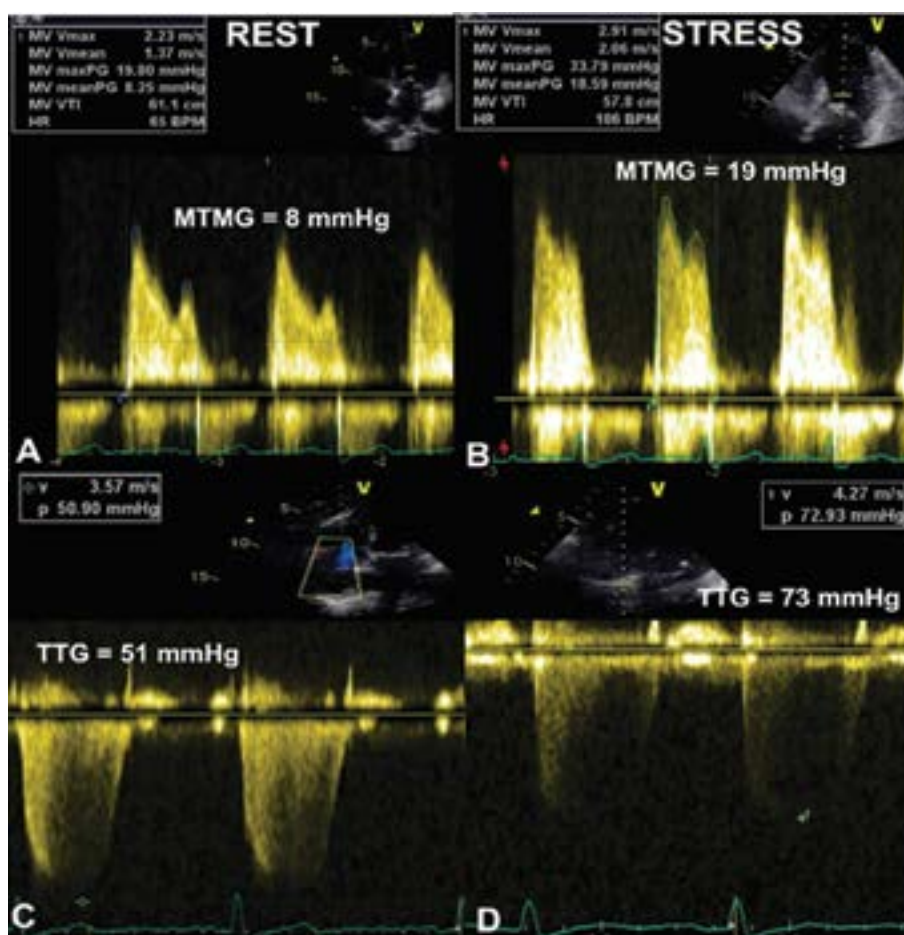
Doppler findings obtained by performing EE in an asymptomatic patient with moderate rheumatic MS (MVA 1.3 cm²) at rest (left panels). The increase in MTMG during exercise was significant (MTMG increased up to 19 mm Hg (A and B) with a significant increase in TTG up to 73 mm Hg (C and D) and exercise-induced dyspnoea. The patient underwent PMC; HR – heart rate; maxPG – maximal pressure gradient; meanPG – mean pressure gradient; MTMG – mean trans-mitral gradient; MV – mitral valve; MVA – mitral valve area; TTG – trans-tricuspid gradient; Vmax – maximal velocity; Vmean – mean velocity; VTI – velocity time integral
